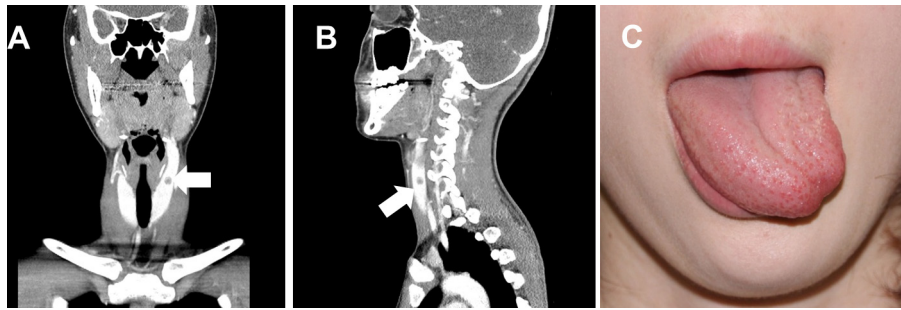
The neck computer tomography (CT) of the patient revealed poor enhancing and well-defined nodules in left upper pole (A and B, white arrow). The tongue of the patient was deviated to the left side indicating of hypoglossal nerve palsy (C), after endoscopic thyroidectomy combined with da Vinci robotic systems.
